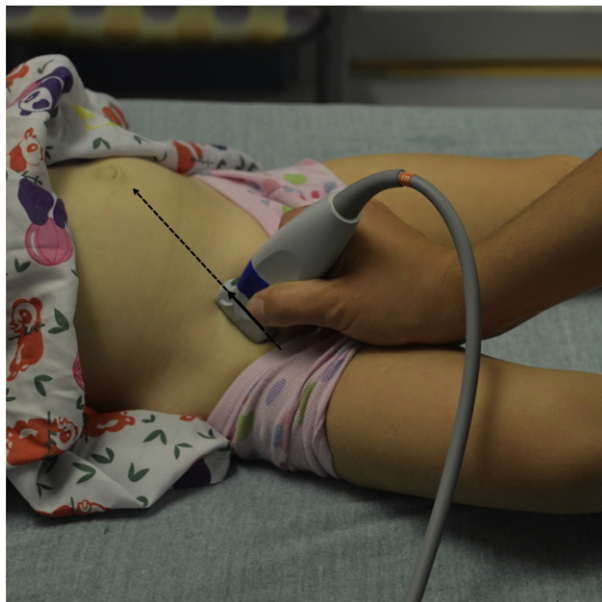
Hip ultrasound position. Ultrasound of the hip with the probe positioned parallel to the femoral neck with the indicator pointing superomedially toward the umbilicus.
